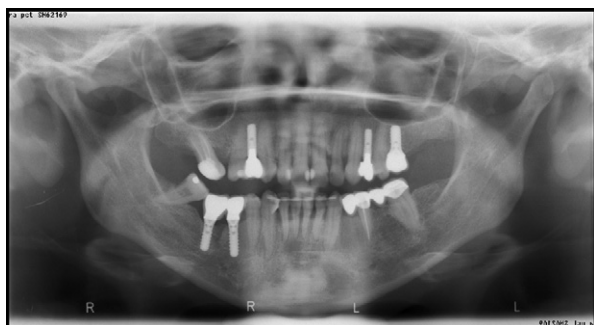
Posttreatment panoramic x-ray.
